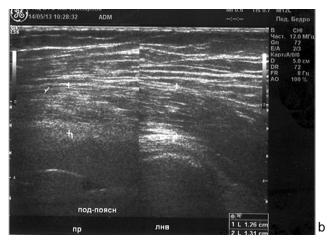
Ultrasound image of iliopsoas of a 52-year-old female patient M. measuring echogenicity (a), thickness of the muscle belly (b)
